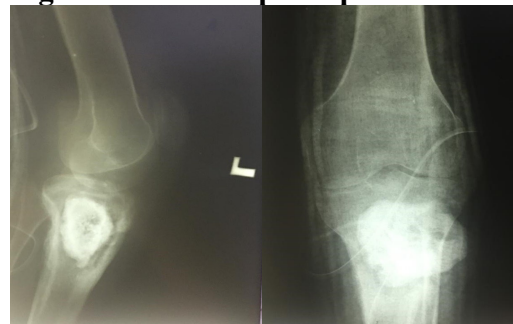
Plain radiographs post operation
